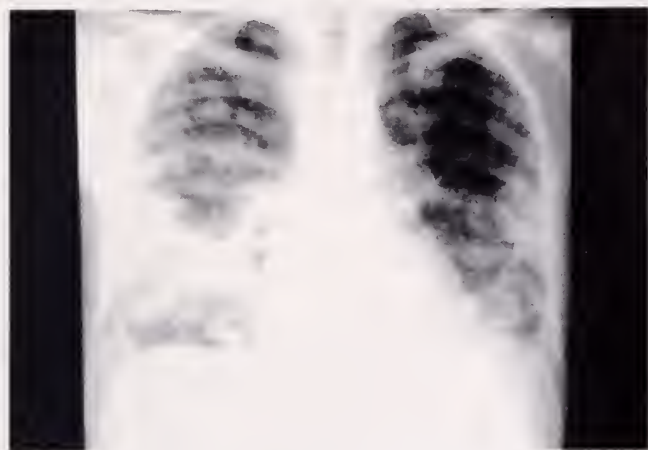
Chest x-ray showing multifocal infiltrates compatible with septic embolization to the lungs.
